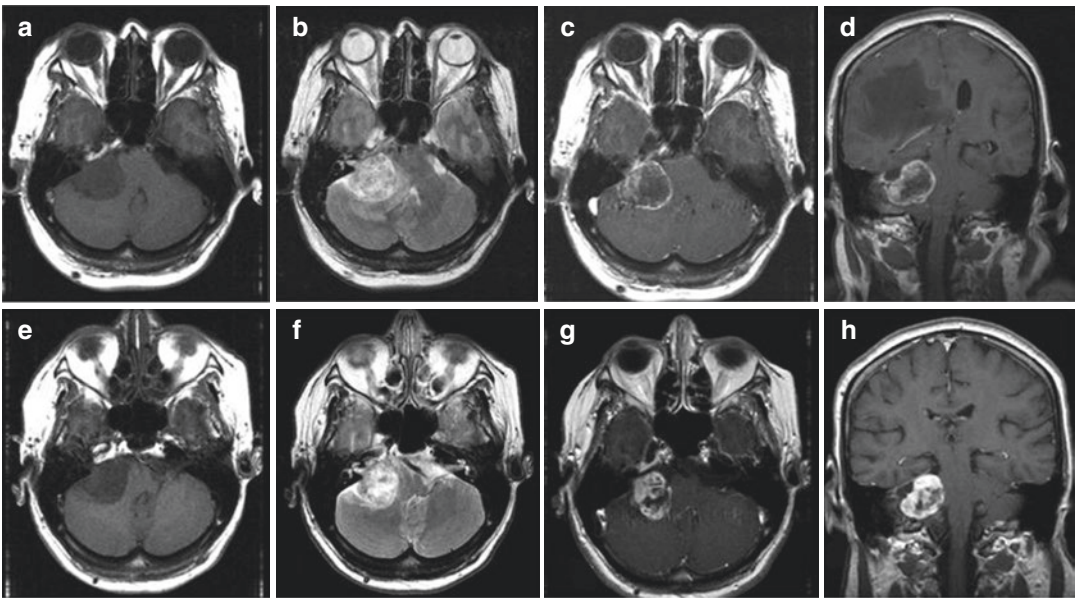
Right vestibular schwannoma in a 60-year-old woman. The patient was admitted with hearing loss on the right side for 4 years. T1- and T2-weighted axial MRIs, and T1-weighted axial and coronal with contrast
